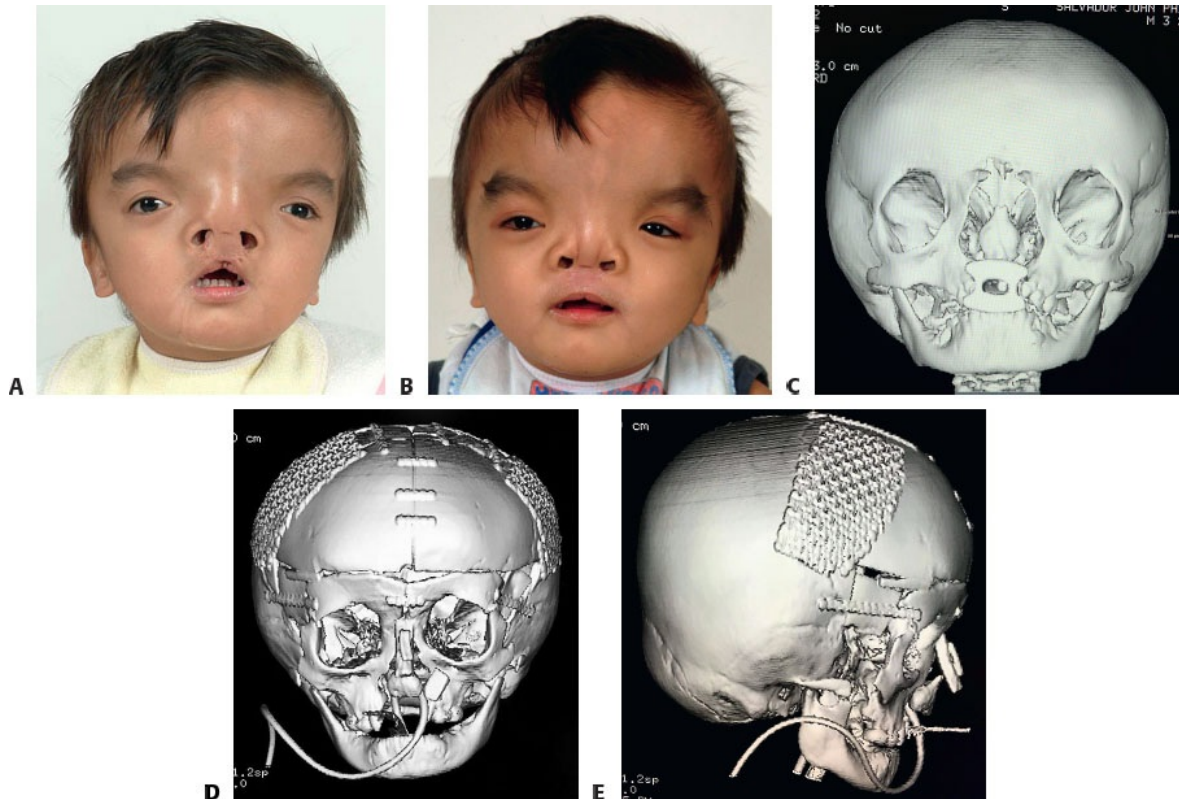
• A 4-year-old boy with severe frontonasal dysplasia and bilateral cleft lip and palate before (A) and 3 months after (B) a facial bipartition with nasal dorsal augmentation using calvarial bone graft. Titanium mesh was used to reconstruct full-thickness calvarial defects. CT images before (C) and immediately after (D,E) reconstruction.
